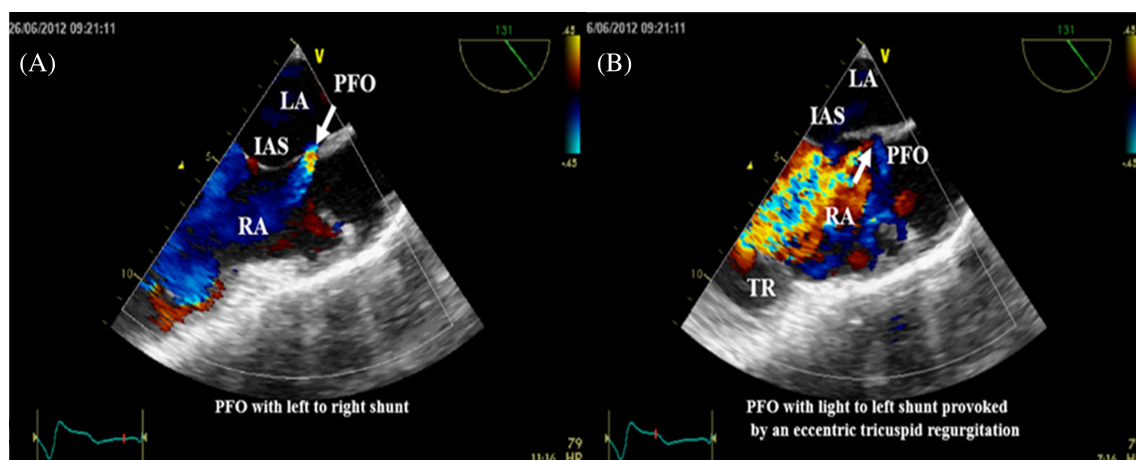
Transesophageal echocardiography mid esophageal long axis view with color Doppler showing a patent foramen ovale with left to right shunting (A) and right to left shunting (B) facilitated by a regurgitant tricuspid flow (favored by a ventricular pacemaker lead) directed toward the IAS. IAS, interatrial septum; LA, left atrium; PFO, patent foramen ovale; RA, right atrium; TR, tricuspid regurgitation
